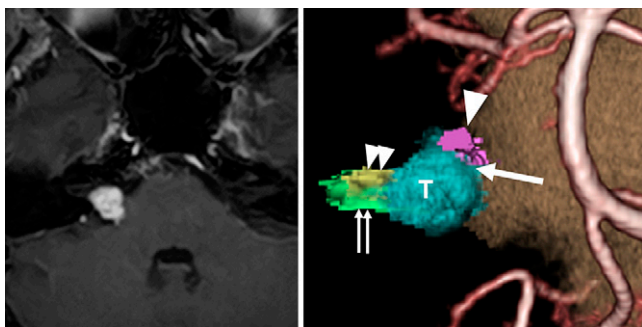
Preoperative axial gadolinium T1-weighted MRI (left) showing a tumor 12 mm in diameter in the right cerebellopontine angle with contrast effect by gadolinium. A 3D-MRC/MRA fusion image (right) showing compression of the trigeminal nerve by the tumor. The distance between the trigeminal nerve and the vestibulocochlear nerve is as short as 3.5 mm. *Large arrowhead* indicates the trigeminal nerve; *long arrow*, the compression site; *double arrowheads*, the facial nerve; and *double arrows*, the vestibulocochlear nerve. T = tumor.
